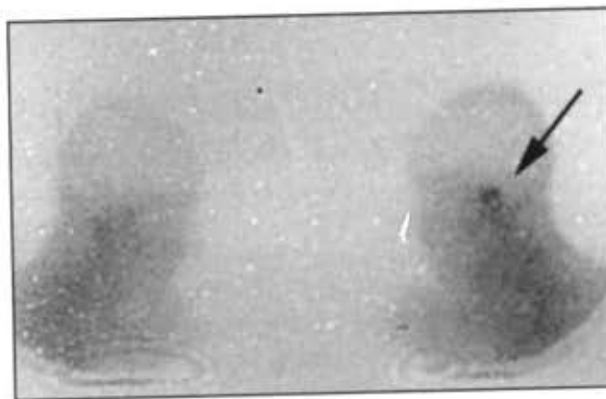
Gallium citrate Ga 67 scintigraphy in a patient left-sided temporal bone osteitis. the left temporal bone shows enhanced uptake of ^{67}Ga (arrow).
